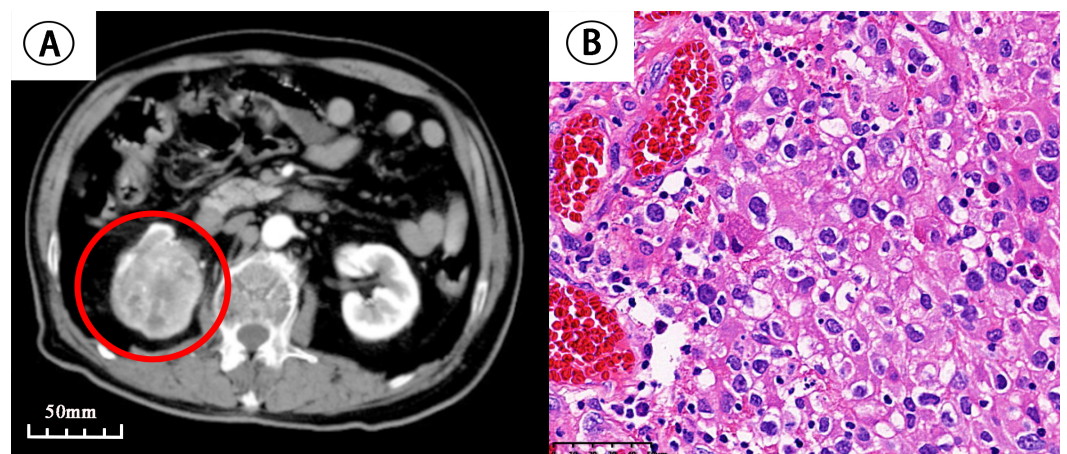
Preoperative abdominal enhanced Computed tomography (CT) revealed a right renal tumour (60 \times 50 \times 40 mm) (A). The location of the tumour is circled in red. The kidney tissue (B, HE \times 400) shows that there is a large amount of glycogen and lipid substances in the cytoplasm, making it appear transparent. Acidophilic granules can be seen in the cytoplasm. The cells are arranged in solid nests, some in tubular, glandular, or papillary arrangements. The interstitium contains abundant capillaries.
